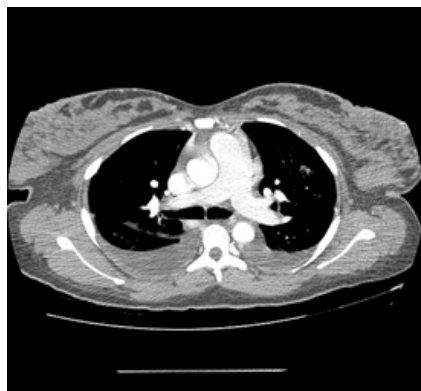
CT scan of chest showing bilateral pleural effusions.
